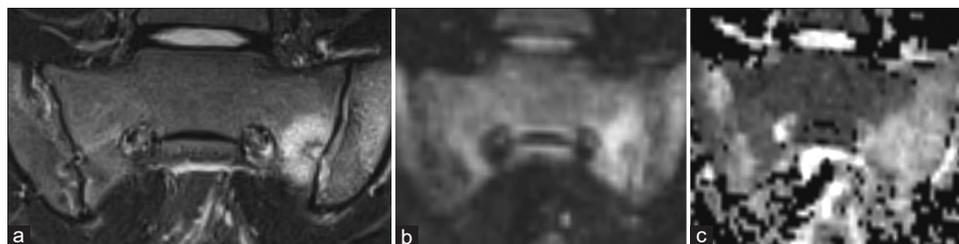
Magnetic resonance imaging of a 17-year-old male with sacroiliitis. (a) MR short tau inversion recovery image demonstrates bone marrow edema in both sacroiliac joints, in particular the left sacroiliac joint. (b) Diffusion-weighted magnetic resonance image ($b = 500 \text{ s/mm}^2$) demonstrates high signal of the bone marrow edema. (c) Apparent diffusion coefficient map demonstrates elevated apparent diffusion coefficient values of bone marrow edema
